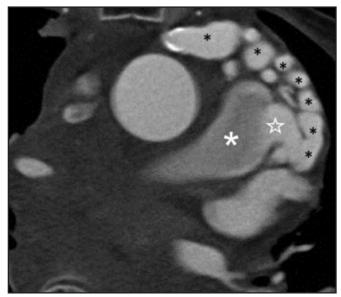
An MIP axial view of a CTA showing a coronarypulmonary fistula (star) seen as a tortuous feeding artery from the RCA (small asterisk) and draining into the MPA (large asterisk).
